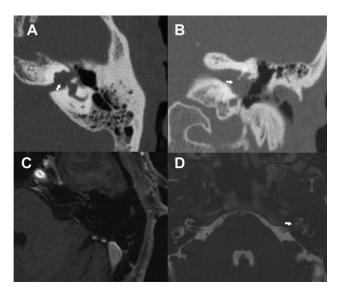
Postoperative radiologic evaluation. (A, B) At high resolution computed tomography (HRCT) scan (axial and coronal view), the outcomes of surgery are visualized, with apparent communication (arrow) between cochlear spaces and the internal auditory canal. The middle ear cavity is well aerated. (C) Axial T1-weighted MRI with gadolinium. The internal auditory canal can be visualized (arrow) without pathologic enhancements. (D) Axial T2-weighted MRI. The surgical outcomes are visualized, with fat graft in place (arrow), separating the subdural spaces of the internal auditory canal from the cochlea.
